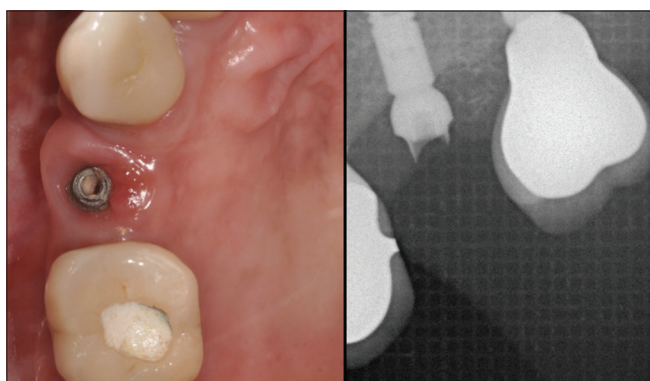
Clinical and radiographic examinations showed the fracture of the abutment of the 25 and a drilling-out crown corresponding to the 26.
